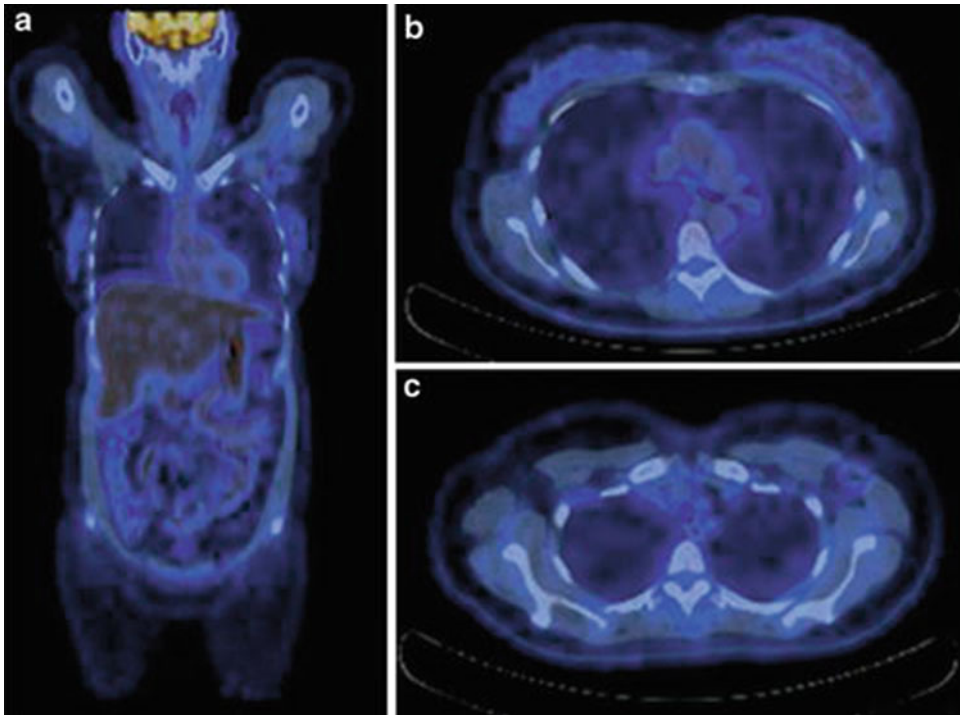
Fused PET/CT images ((a) coronal, (b, c) transaxial) after chemotherapy completion show the disappearance of the previously detected pathological [^{18}F]FDG uptake in left breast and in regional lymph nodes
